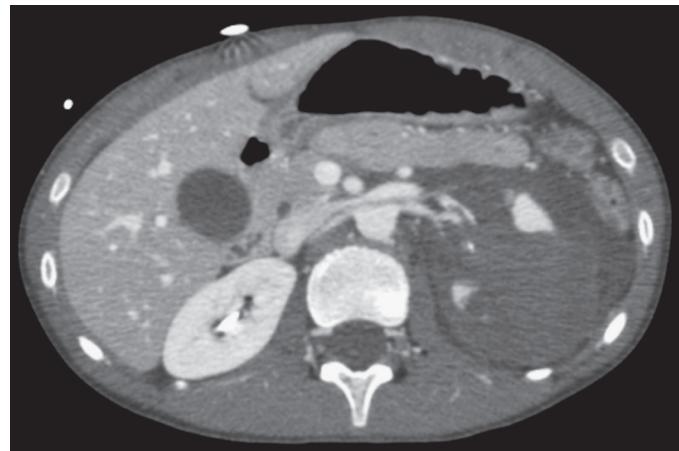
Traumatic Injury to the Left Kidney. Contrast CT demonstrates large left renal perfusion defect caused by acceleration-deceleration trauma of the renal pedicle, resulting in vascular injury and kidney rupture as well as injury of the urinary collecting system.
